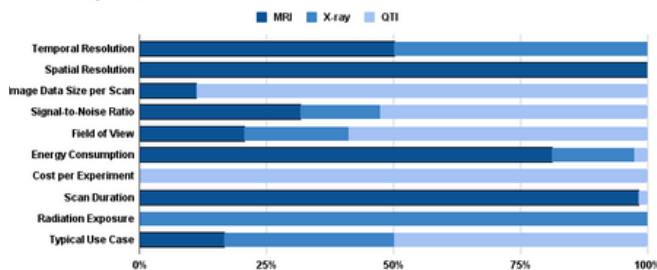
a comparison between QTI, X-Ray, and MRI
